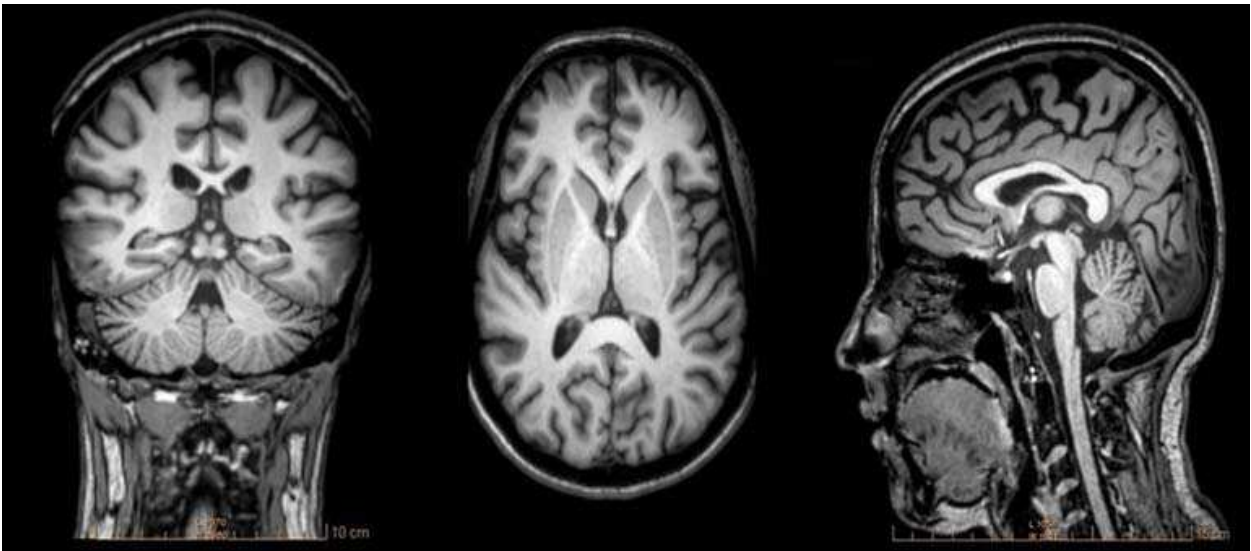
T1-weighted MRI scans acquired in coronal (left), axial (center) and sagittal (right) planes with 3 T. All images were acquired with a field of view of 25 cm and 256 x 256 matrix, 1-mm slice thickness. Image was acquired using a turbo field echo sequence, gated to achieve an effective TR of >8 ms and TE of 4 ms. Left: Coronal image passing through lateral ventricles and temporal lobes. Center: Axial image passing through the lateral ventricles and basal ganglia. Right: Mid-sagittal image highlighting the corpus callosum, brain stem and cerebellum
